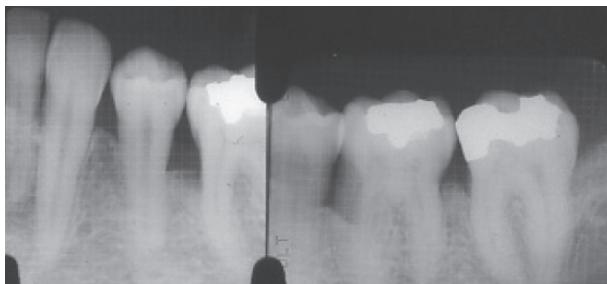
Case 5 - Radiographs taken 2 and 13 years post-treatment
